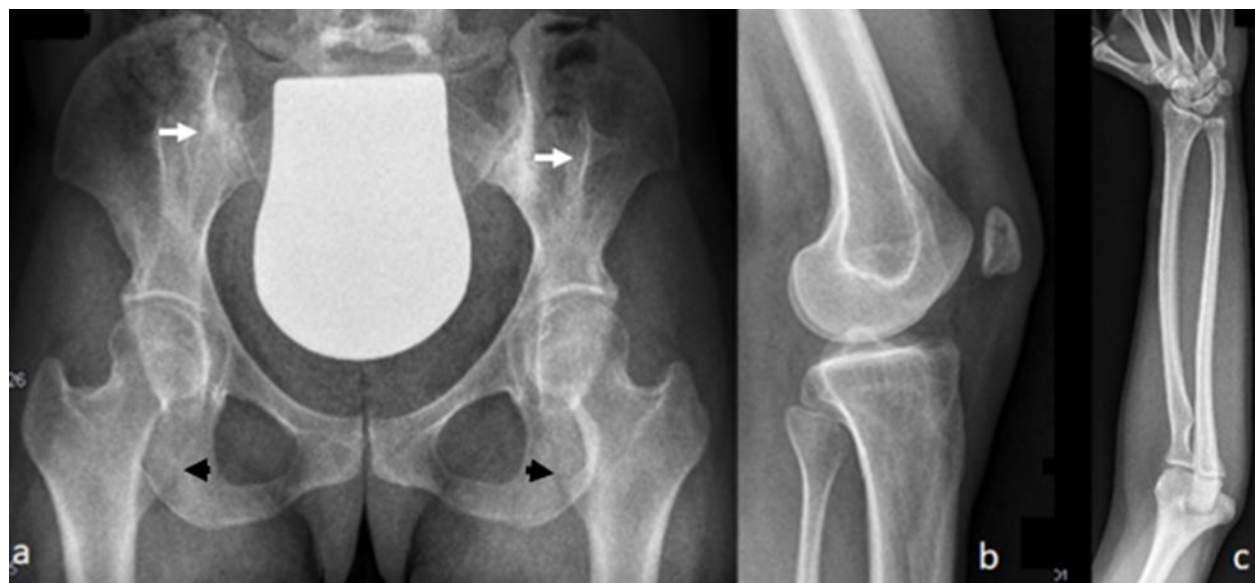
A 35-years-old female patient with a history of arthralgia (knee and groin pain) since post adulthood. AP standing pelvis radiograph showed coxa valga, apparent iliac horns (bilateral flaring of the iliac wings-arrows). The Neck-Shaft Angle (NSA) in this patient appears beyond 134.4° . Apparent massive encroachment of the medial aspect of the neck femur and the lesser trochanters onto the ischium (black arrow heads) leads to narrowing of the ischiofemoral and quadratus femoris space with a clinical and radiological diagnosis of ischio-femoral impingement syndrome (a). Note the zero distance between the ischium and the lesser trochanters causing massive and evident impingement, in addition there was a notable hypertrophy of the lesser trochanters (arrow heads). Lateral knee radiograph showed dysplastic and a dislocated patella (b). AP radiograph of the elbow showed impingement of the olecranon with subsequent development of difficulties in pronation and supination (c).
